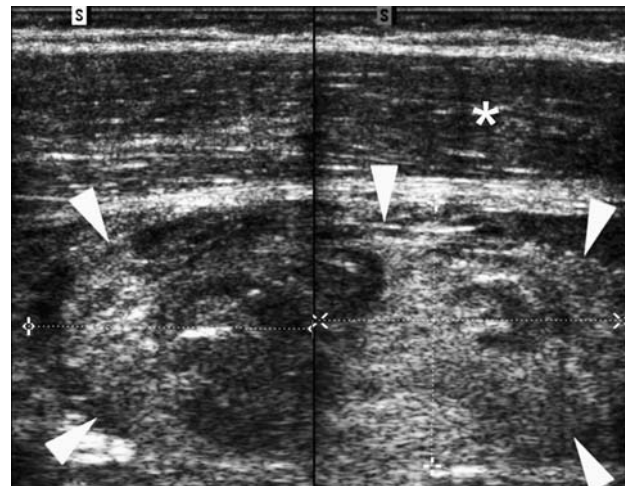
Sonography 24 h after the trauma. Sonography (7.5 MHz transducer) 24 h after the trauma reveals circumscribed haematoma (arrowheads) within the vastus intermedius muscle. Normal appearance of the rectus femoris muscle (asterisk)
